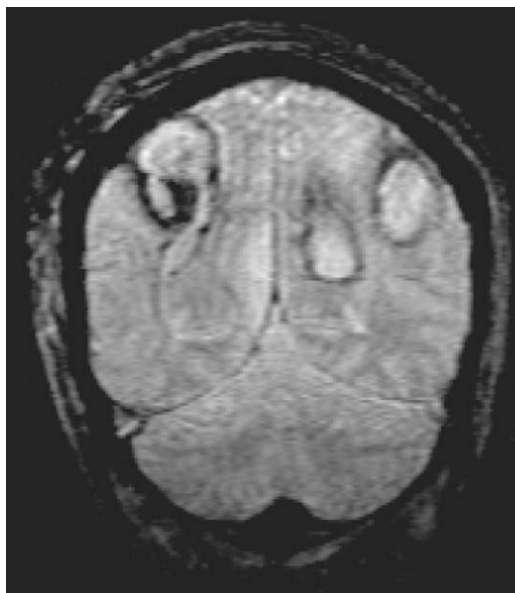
T2 Gradient-echo MRI image demonstrating multiple ICHs.
